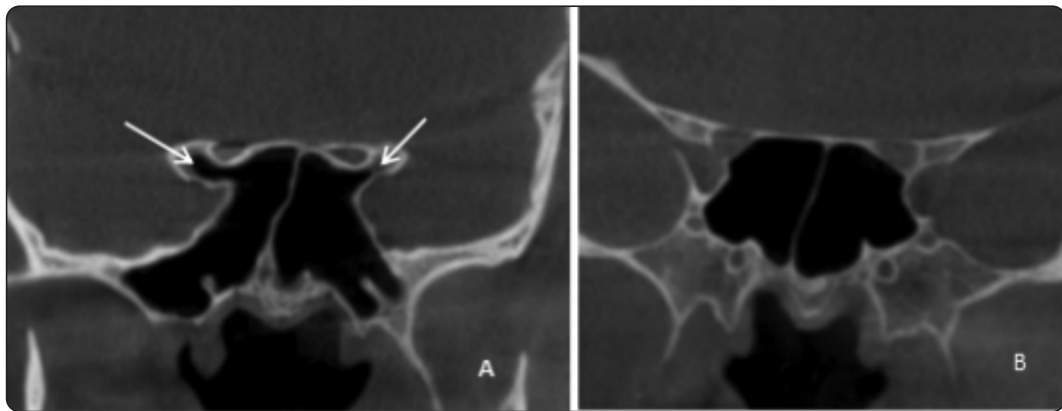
Coronal cuts of CBCT showing: A: bilateral lesser wing pneumatization (white arrows) and full lateral pneumatization, B: no lesser wing pneumatization and no lateral pneumatization.
